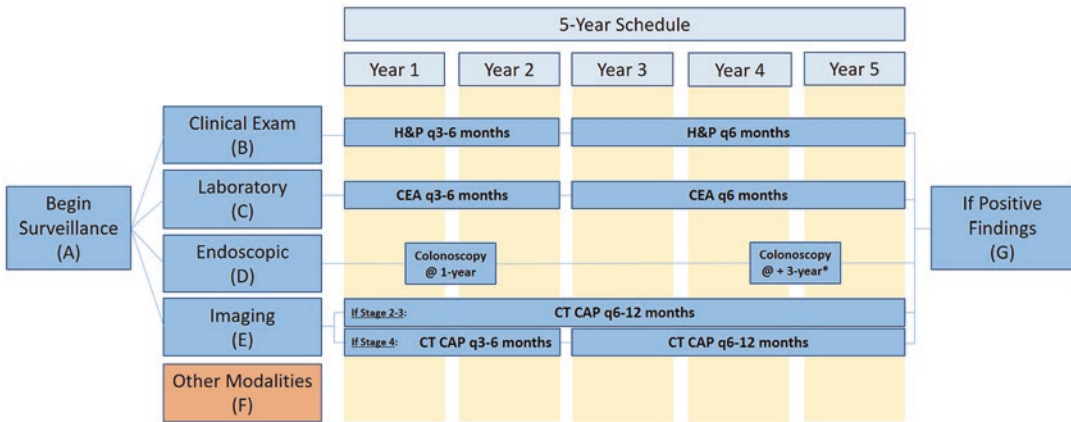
Recommended algorithm for postoperative surveillance for rectal cancer. Surveillance begins after surgical staging (A) and uses the clinical exam (B), laboratory studies (C), endoscopic tests (D) and imaging (E). Other modalities (F) such as PET/CT and FIT/fecal DNA
